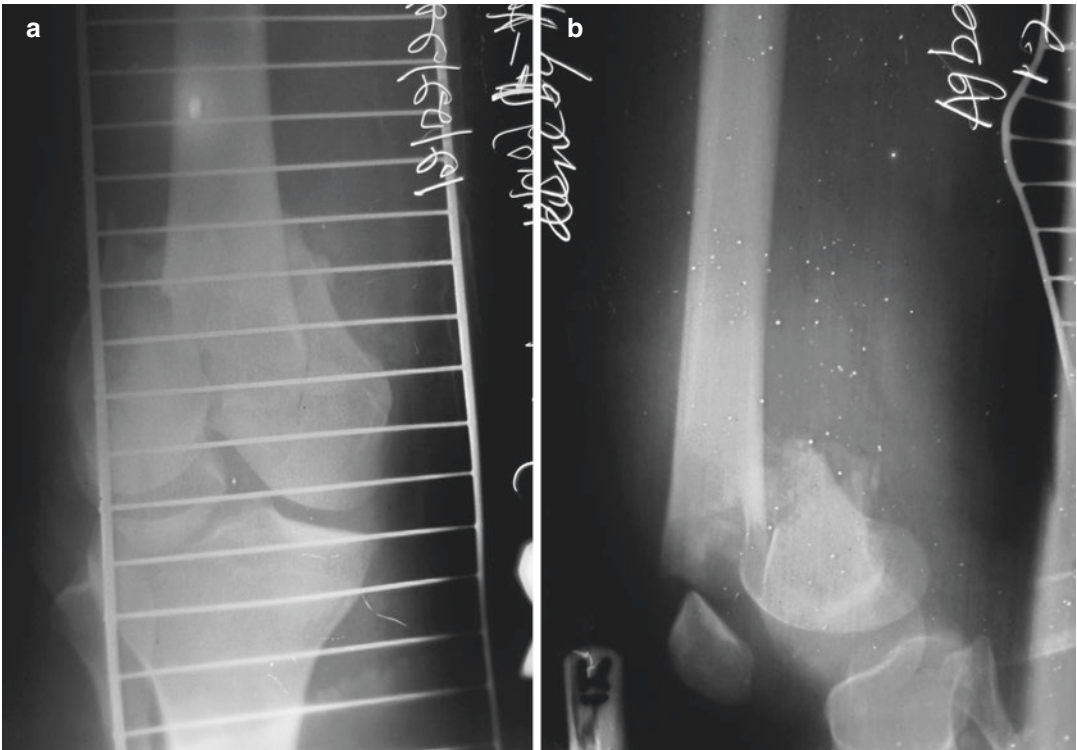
(a, b) X-rays of a closed low Y-type intra-articular distal femur fracture. (c, d) ORIF by reestablishing the condyles with two compression screws and gentle insertion of a retrograde SIGN nail. Only one locking
